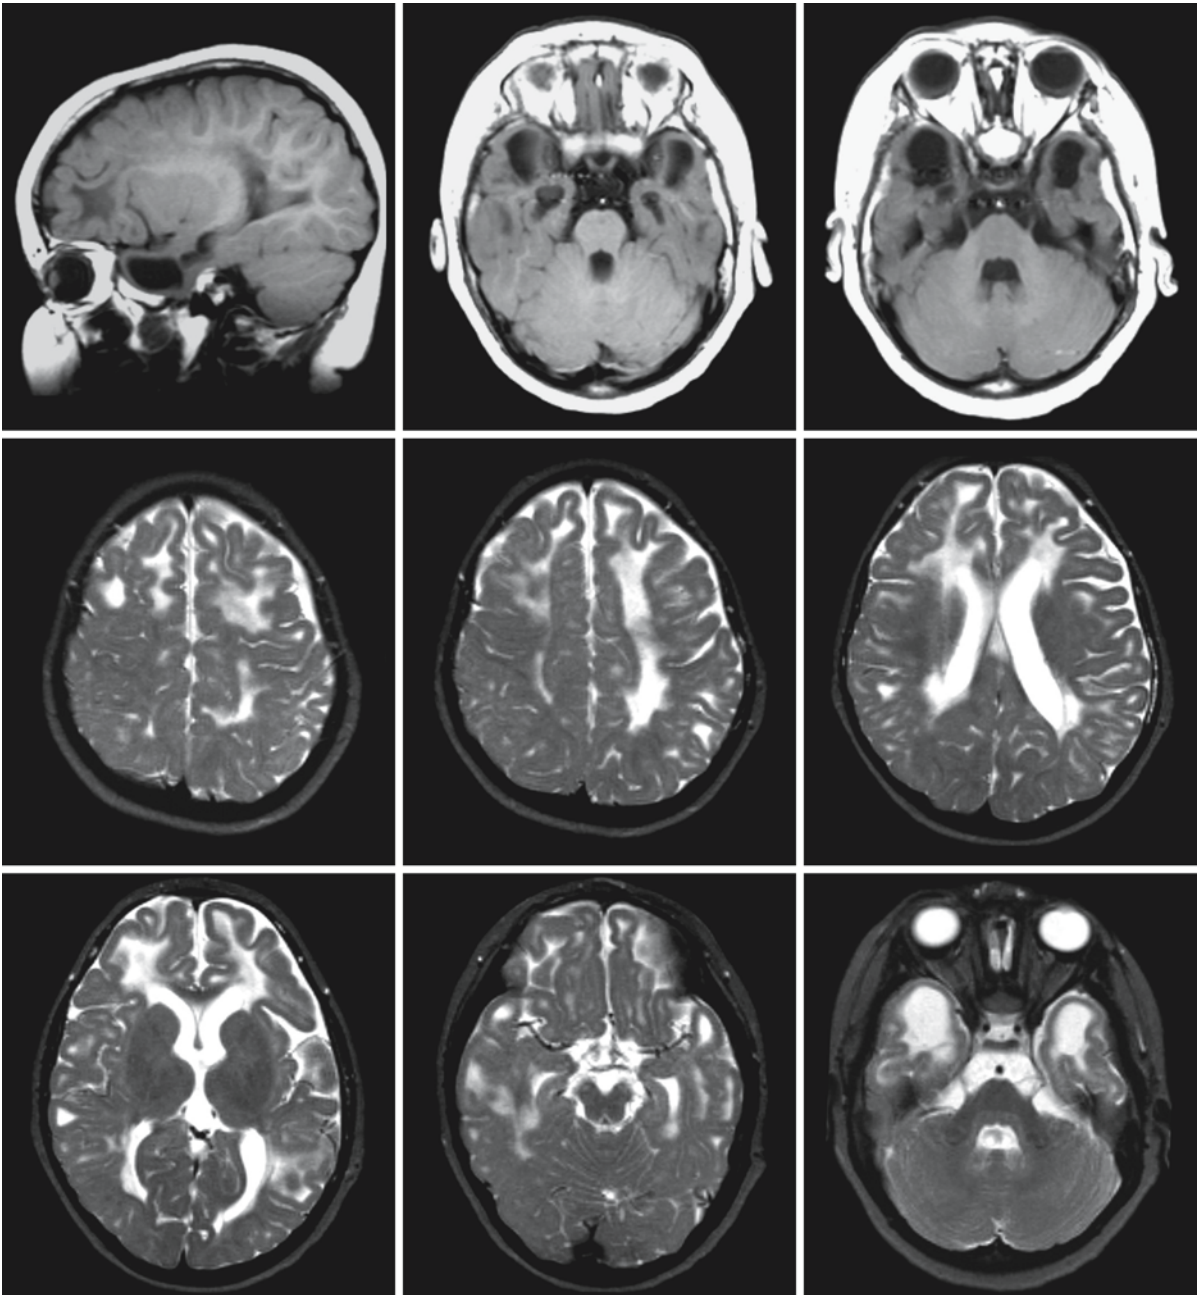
MRI of the same patient as shown in Fig. 66.1 at the same age. The T₁-weighted images show cysts in the anterior temporal region. The T₂-weighted images show extensive
